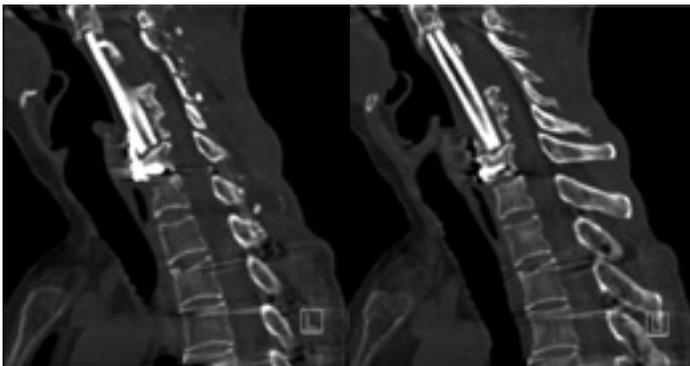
CT scan of cervical spine three months postoperatively demonstrating stable positioning of free fibula graft.
